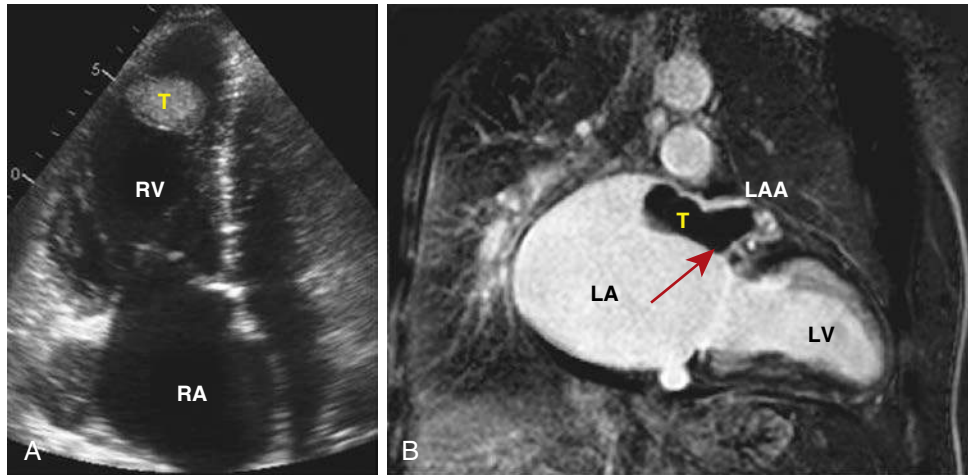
A, Transthoracic echocardiogram (four-chamber view) showing a thrombus in the right ventricle. B, Cardiac magnetic resonance showing a thrombus in the left atrial appendage (red arrow). LA, Left atrium; LAA, left atrial appendage; LV, left ventricle; RA, right atrium; RV, right ventricle; T, thrombi.
